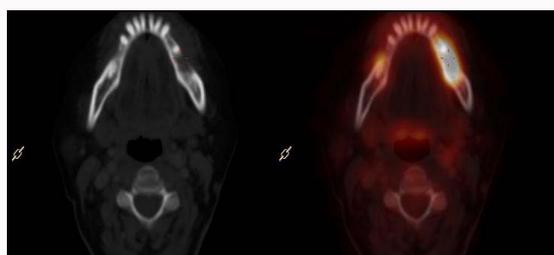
Pre-treatment PET CT-scan images showing lytic lesion in left side of mandible in the first molar tooth region.
